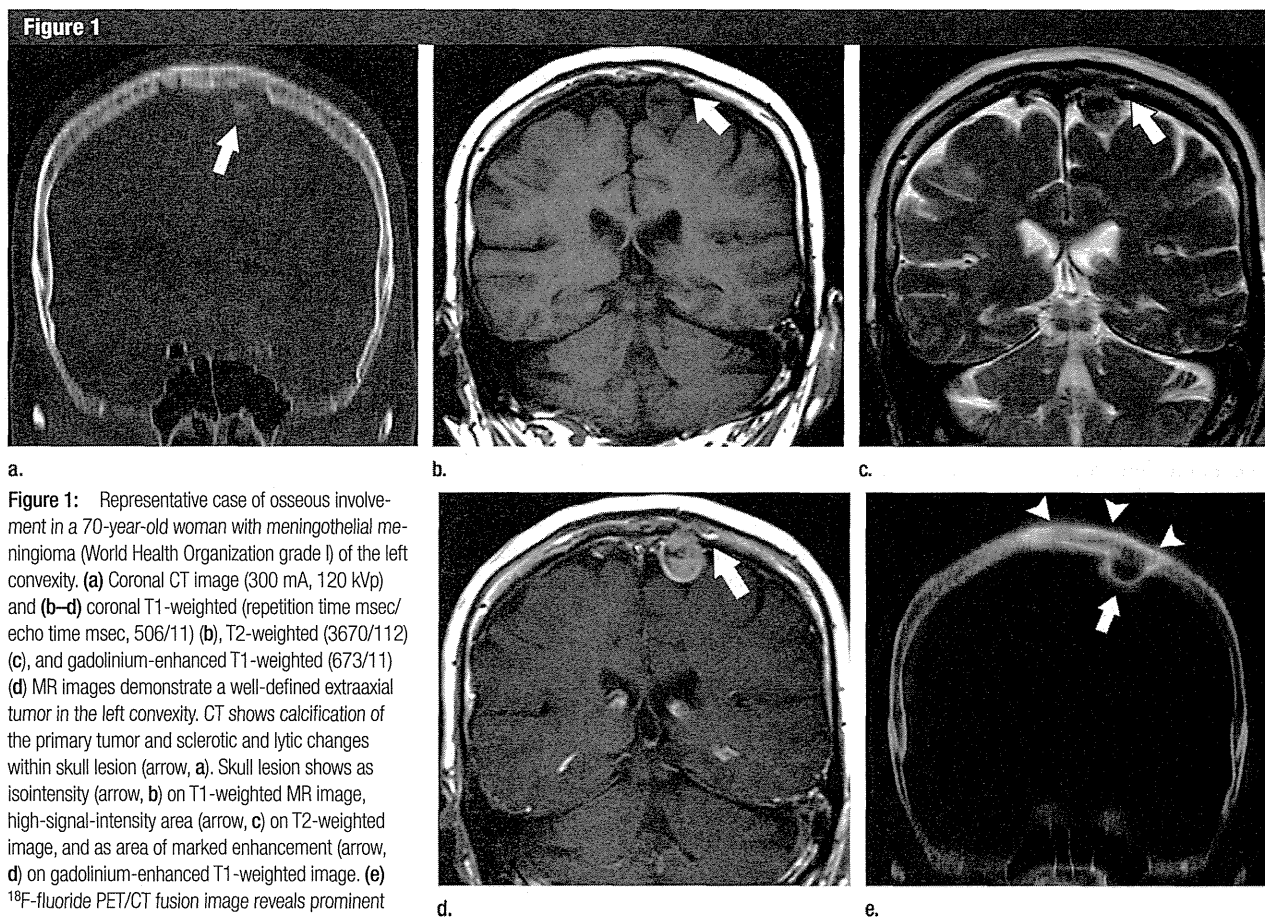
Representative case of osseous involvement in a 70-year-old woman with meningothelial meningioma (World Health Organization grade I) of the left convexity. (a) Coronal CT image (300 mA, 120 kVp) and (b–d) coronal T1-weighted (repetition time msec/echo time msec, 506/11) (b), T2-weighted (3670/112) (c), and gadolinium-enhanced T1-weighted (673/11) (d) MR images demonstrate a well-defined extraaxial tumor in the left convexity. CT shows calcification of the primary tumor and sclerotic and lytic changes within skull lesion (arrow, a). Skull lesion shows as isointensity (arrow, b) on T1-weighted MR image, high-signal-intensity area (arrow, c) on T2-weighted image, and as area of marked enhancement (arrow, d) on gadolinium-enhanced T1-weighted image. (e) ^{18}F -fluoride PET/CT fusion image reveals prominent uptake both in the primary tumor (arrow) and in the skull containing osseous involvement (arrowheads). Normal skull shows minimal uptake.
